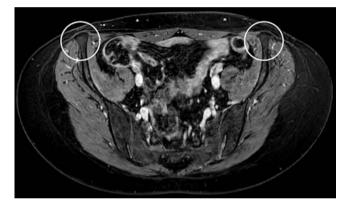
Example of transverse T1-weighted, fat-suppressed THRIVE sequence of the pelvis, in which the iliac crest on both sides can be easily identified for preoperative measurements (circles)
